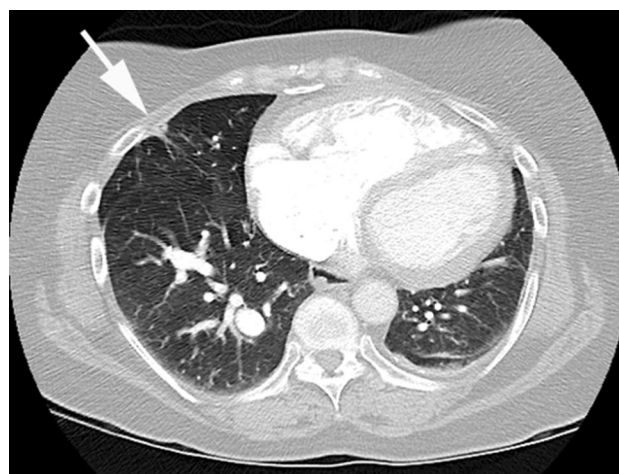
62-year-old woman with a history of pulmonary embolism. Axial CT of the chest demonstrates a healed infarct in the right middle lobe (arrow)
